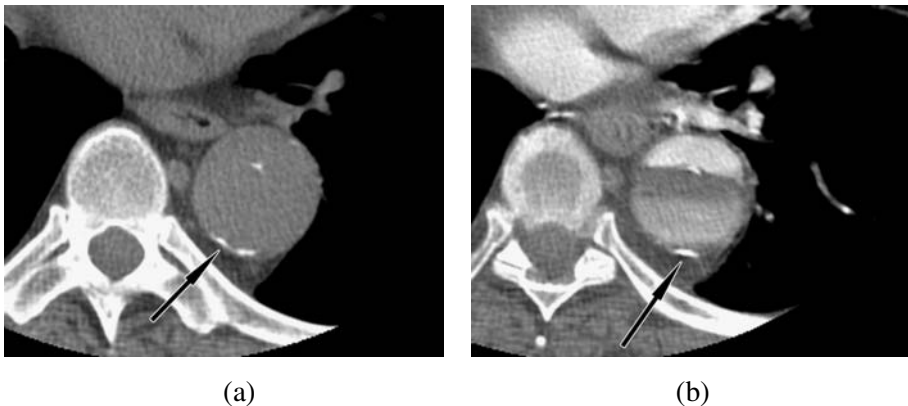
Axial CT images of chronic classic dissection demonstrates calcification of the dissection flap and the outer wall of the false lumen (black arrows in (a) and (b): (a) unenhanced image; (b) contrast-enhanced image (note low attenuation of the false lumen on the contrast-enhanced image due to slow flow and early image acquisition).
